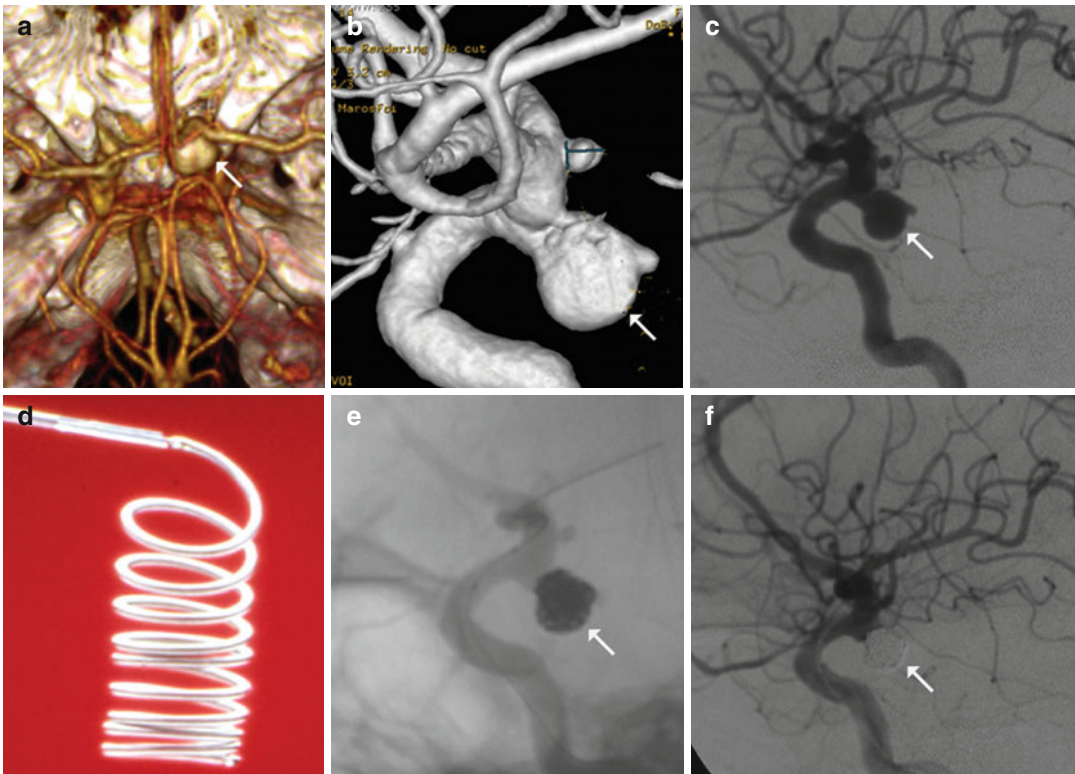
Aneurysm of the Internal Carotid Artery (ICA) – Posterior Communicating Artery (PCoM) and its neurointerventional treatment with microcoils (a) CT angiography (CTA). The aneurysm in the posterior wall of the ICA is indicated by an *arrow*. (b) Digital Subtraction Angiography (DSA): left ICA contrast angiography, 3D reconstruction. The aneurysm is indicated by an *arrow*. (c) DSA left ICA contrast angiography, lateral 2D image of the angiography. The aneurysm is indicated by an
